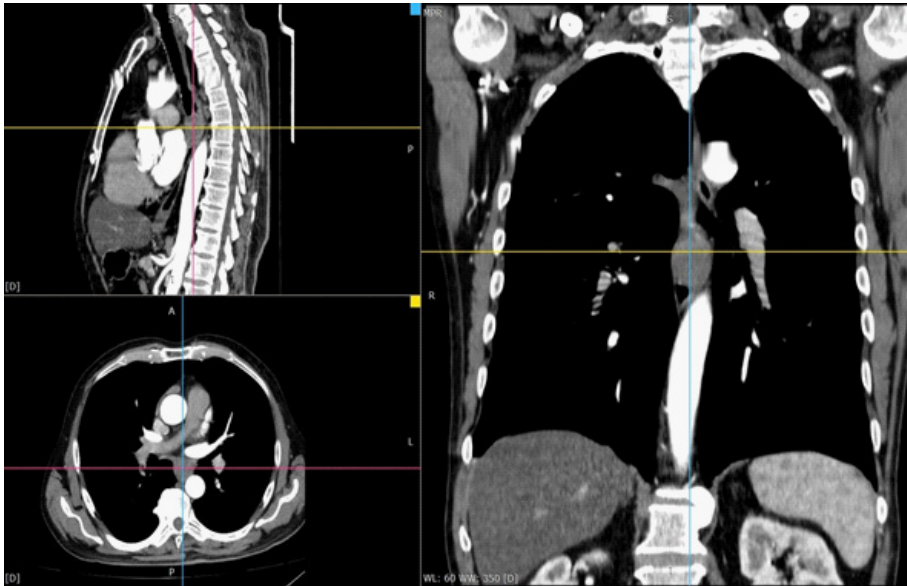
CT of the thorax shows leiomyoma of the esophagus.
